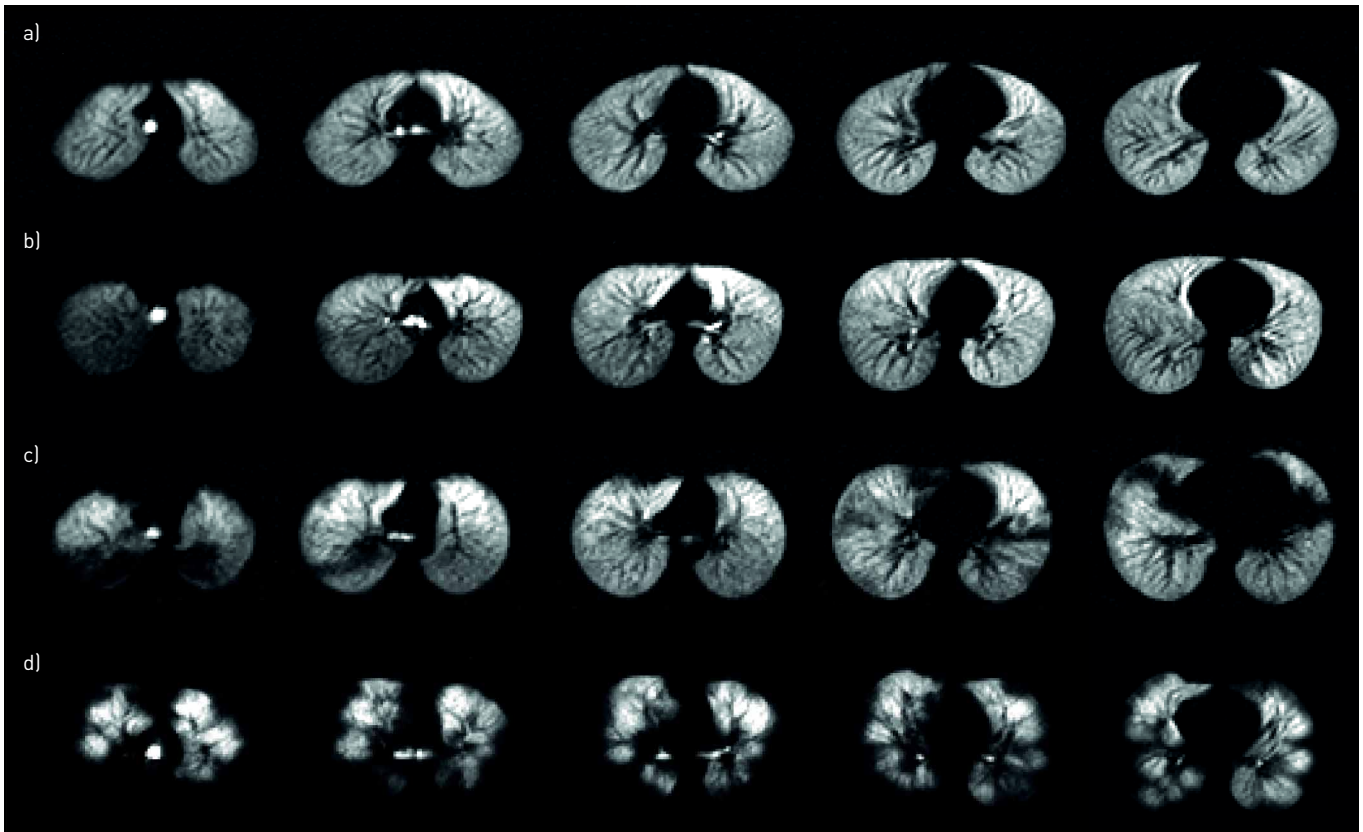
Representative axial xenon-129 (^{129}Xe) ventilation magnetic resonance images from four haematopoietic stem cell transplantation (HSCT) patients demonstrating the range of ^{129}Xe ventilation patterns seen in this study. a) 15-year-old female, 145 days post-HSCT, forced expiratory volume in 1 s (FEV₁) 108% predicted, ^{129}Xe ventilation defect percentage (VDP) 3.0%; the subject has high FEV₁ % pred, ventilation is homogenous and the ^{129}Xe VDP is correspondingly low. The sensitivity of ^{129}Xe MRI to mild lung abnormalities is demonstrated in the subjects in b) [15-year-old female, 3 years post-HSCT, FEV₁ 81% pred, ^{129}Xe VDP 2.6%] and c) [13-year-old female, 93 days post-HSCT, FEV₁ 81% pred, ^{129}Xe VDP 20%], both of whom have similar high FEV₁ % pred, yet the subject in c) has large focal deficits (e.g. posterior left and right lungs near apices, anterior right lung near the base) and higher VDP. d) 13-year-old female, 9 years post-HSCT, FEV₁ 52% pred, ^{129}Xe VDP 41.4%. ^{129}Xe ventilation is very heterogeneous with large deficits and correspondingly high ^{129}Xe VDP and low FEV₁ % pred.
